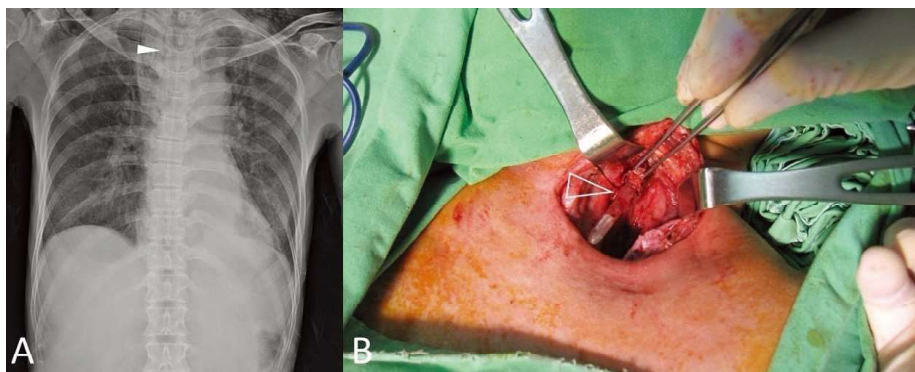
(A) Chest roentgenogram revealing massive subcutaneous emphysema extending from the neck to the chest wall (white arrowhead). (B) An intraoperative image showing transection of the cervical esophagus, with only a short proximal stump (hollow arrowhead).
